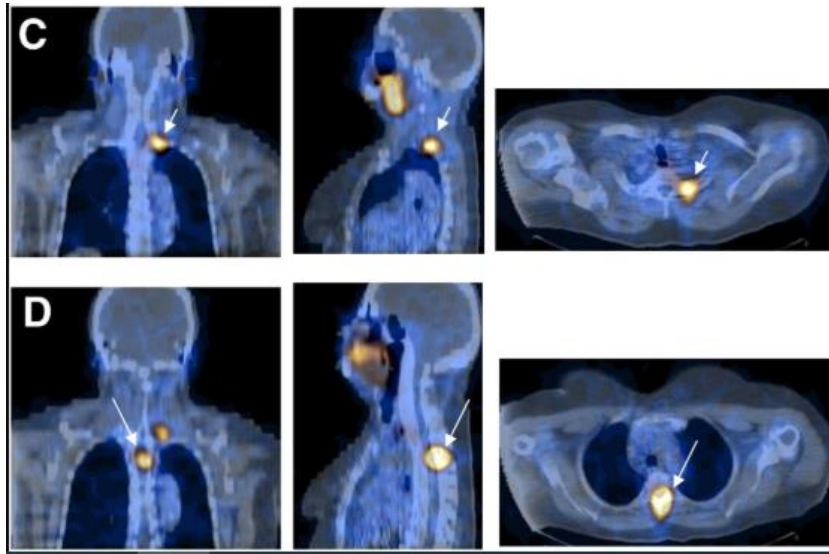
SPECT-CT image fusion (C and D) in coronal, sagittal and transverse slices
